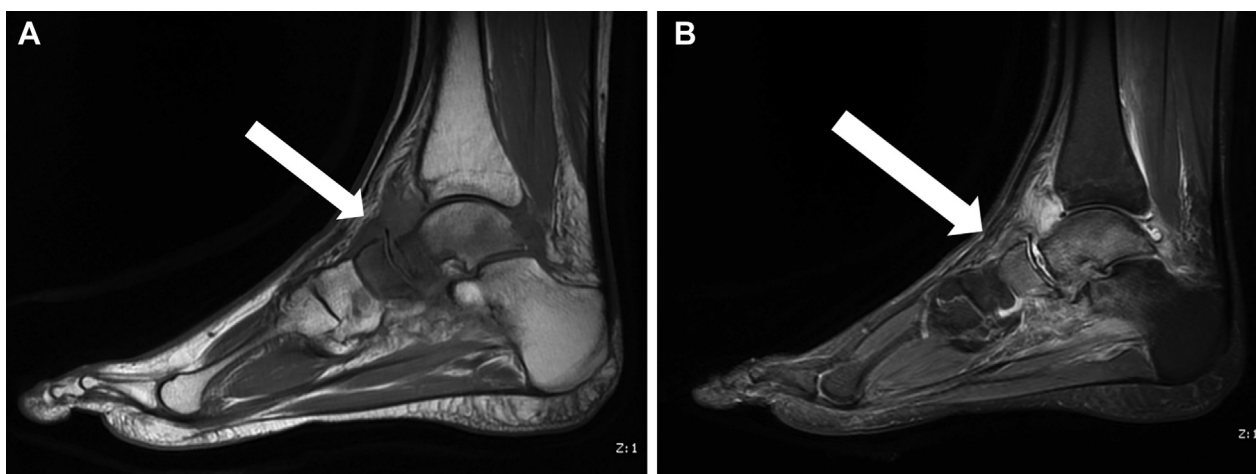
T1- (A) and T2- (B) weighted magnetic resonance images of the right foot showing a significant resorptive collapse of the talar head with marked marrow edema in the neck (arrows). There is also marked edema of several other midfoot bones and the small muscles of the foot. The differential diagnosis of these presentations is avascular necrosis or CN. CN = Charcot neuroarthropathy.
